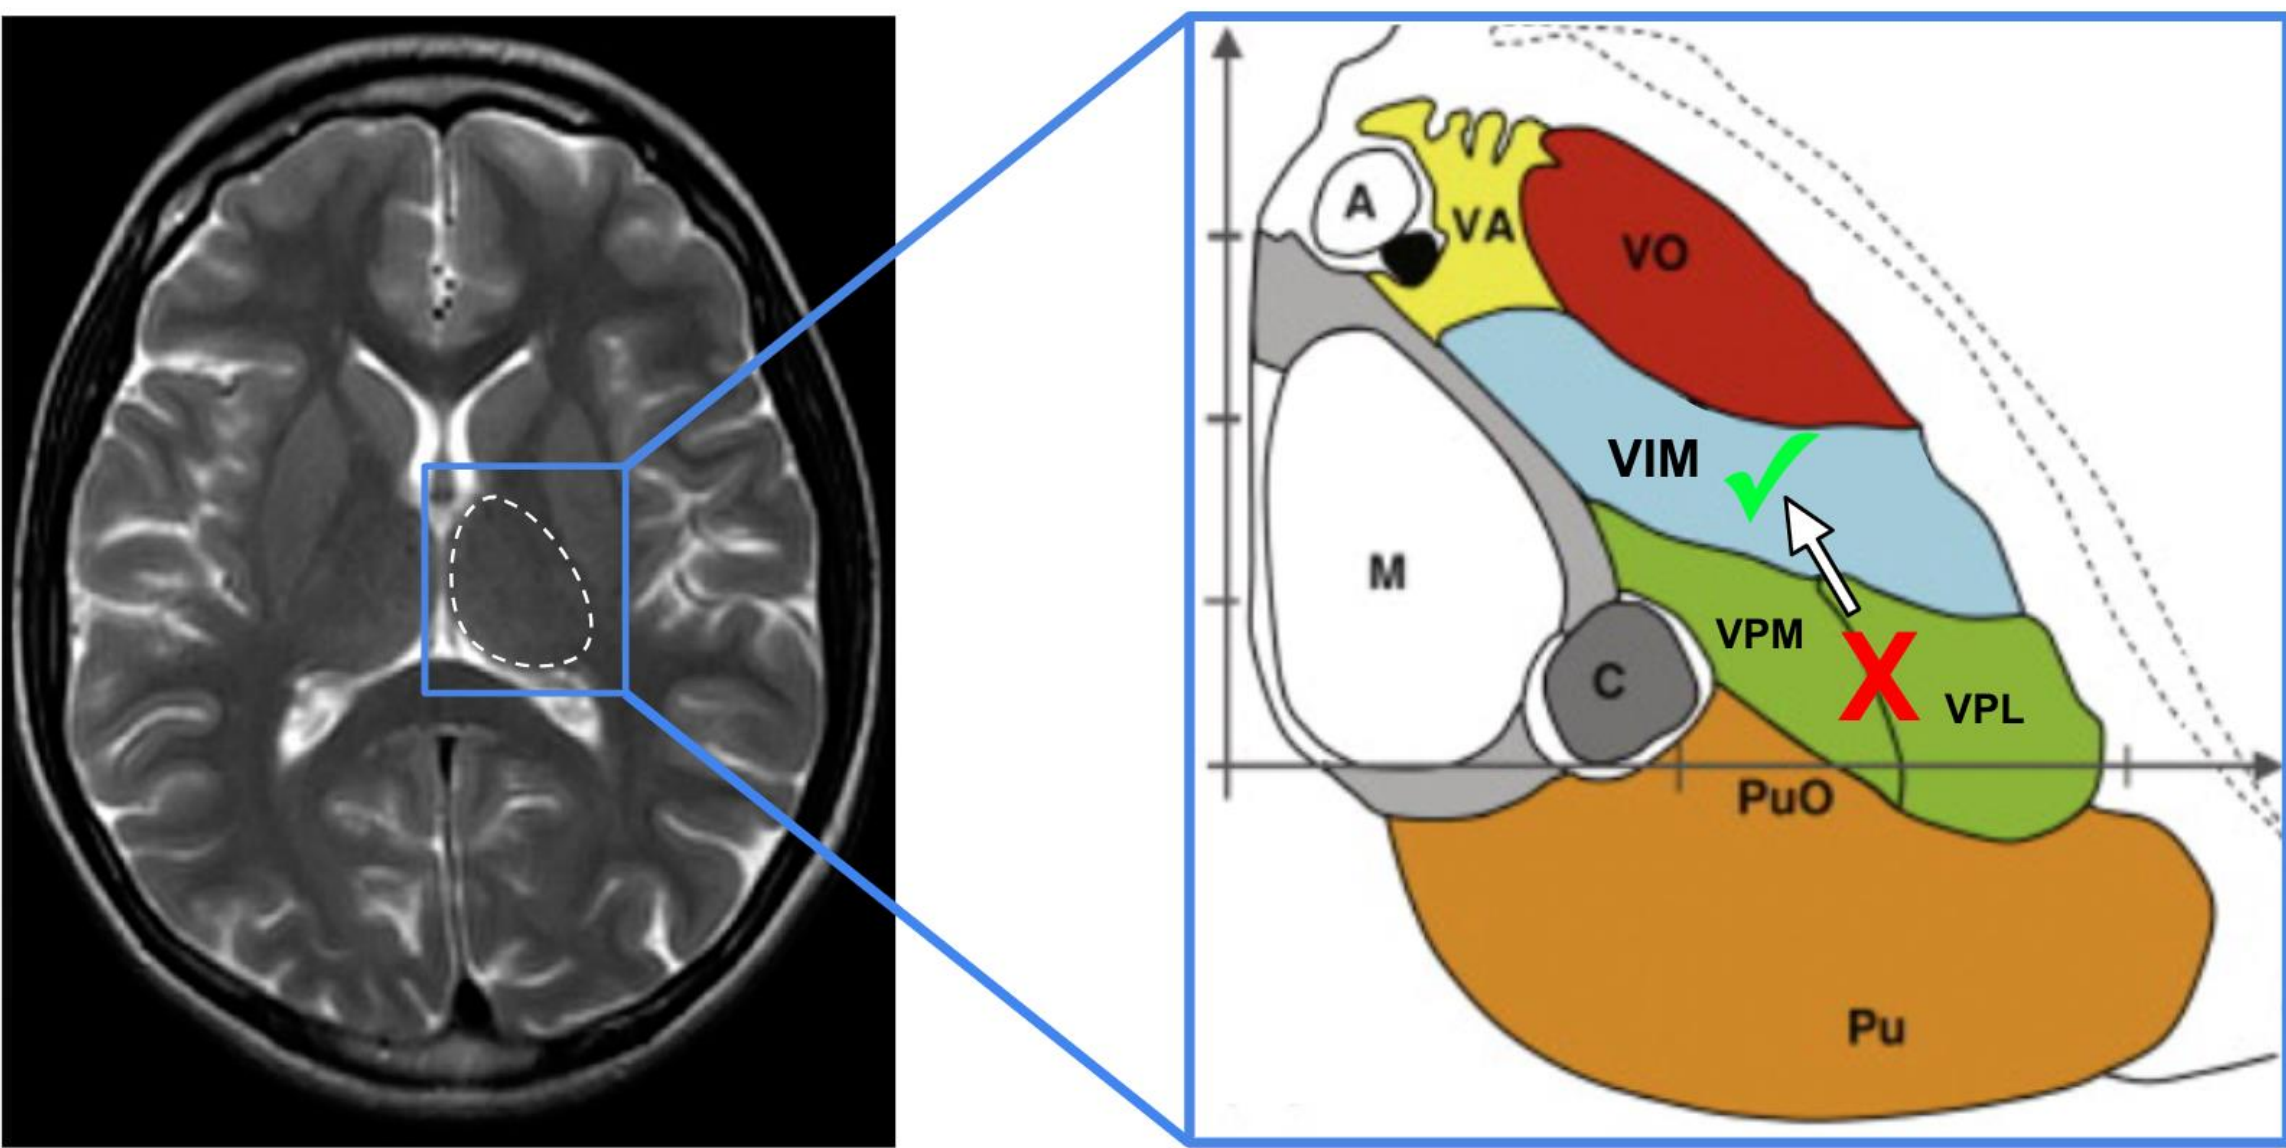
Axial T2 MRI of the left thalamus (left) with corresponding nuclei (right). The VIM (blue) is located anterior to the VPM and VPL (green). The VIM is the intended target in FUS for ET (✓), while the VPM and VPL are avoided (✗). Adapted from Mai JK, Forutan F. Thalamus. In: Mai JK, Paxinos G, eds. *The Human Nervous System*. Academic Press; 2012:618–677.
